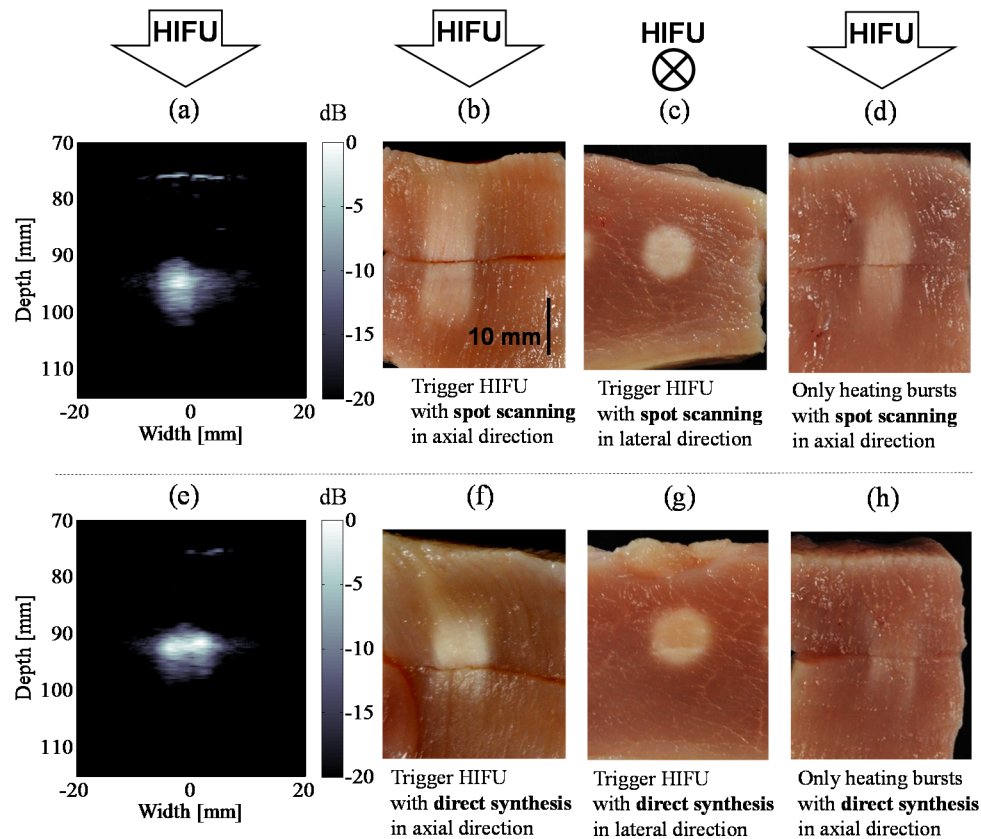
Typical ultrasound images of cavitation bubbles during HIFU exposure and slices of chicken tissue samples after HIFU exposure [35]. Heating bursts with spot scanning and direct synthesis were exposed for (a–h), respectively. Trigger HIFU sequences shown in Figure 1b,c were used for (a–c,e–g), respectively; (a,d) variance images of high-speed pulse inversion data by transmitting diverging waves; (b,f) the gross pathology in the longitudinal cross section; (c,g) the gross pathology in the lateral cross section; and (d,h) the gross pathology in the longitudinal cross section without trigger pulses.
